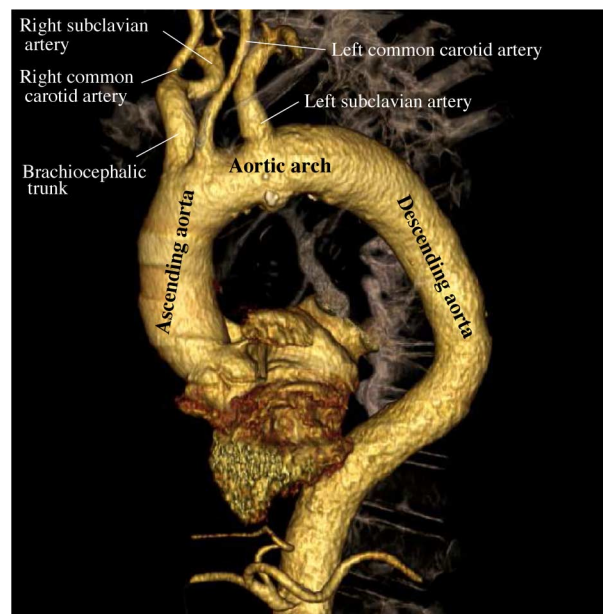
Anatomy of the thoracic aorta (volume rendering of a CTA dataset).
